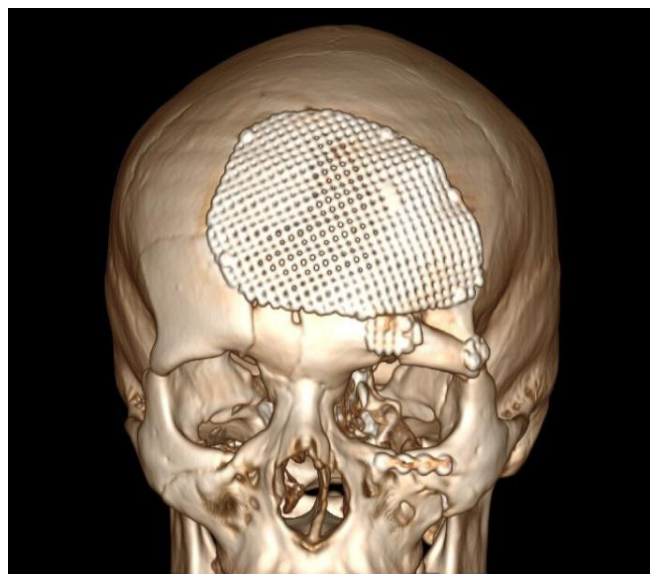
Computed tomography: 3D skull reconstruction, frontal view. A titanium mesh is visualized in the projection of the frontal bone defect. The image shows frontal lobe fragments forming the superior orbital wall after osteosynthesis
